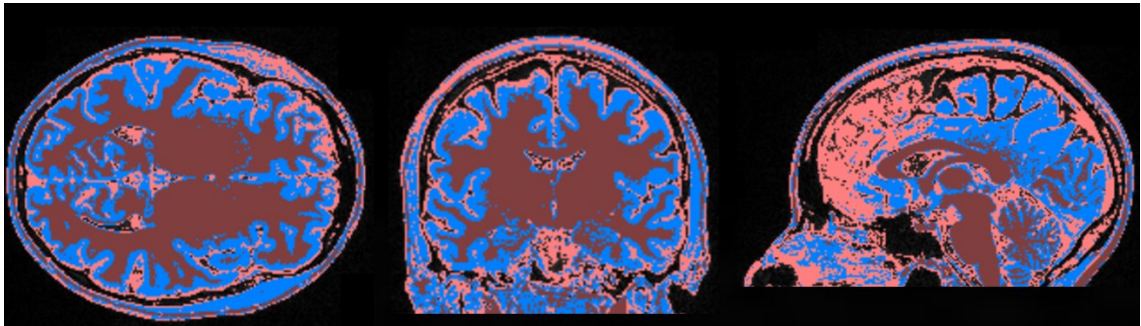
Threshold-based segmentation without post-segmentation correction of MRI images in Figure 4.1.
